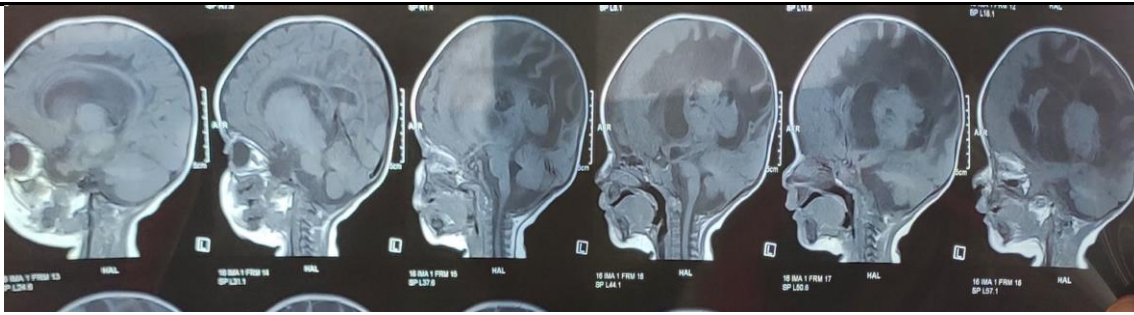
MRI of the patient
